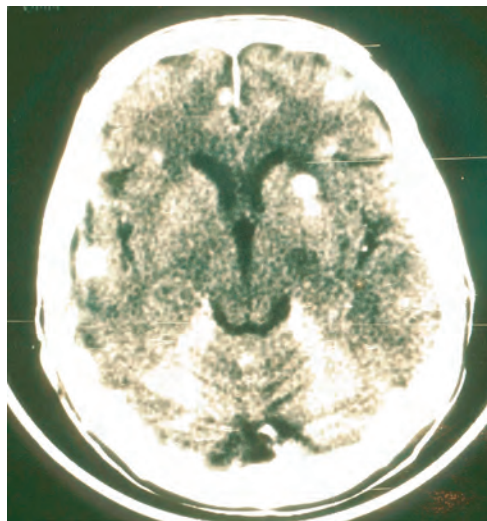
CT scans of the brain can detect small lesions. In this patient, several lesions are identified in both hemispheres.
